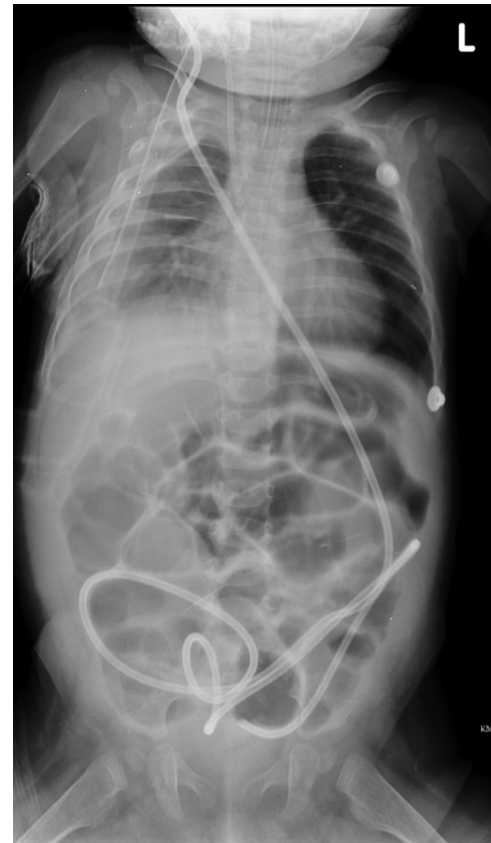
Chest roentgenogram showing shunt migration into the pleural space and pleural effusion.
